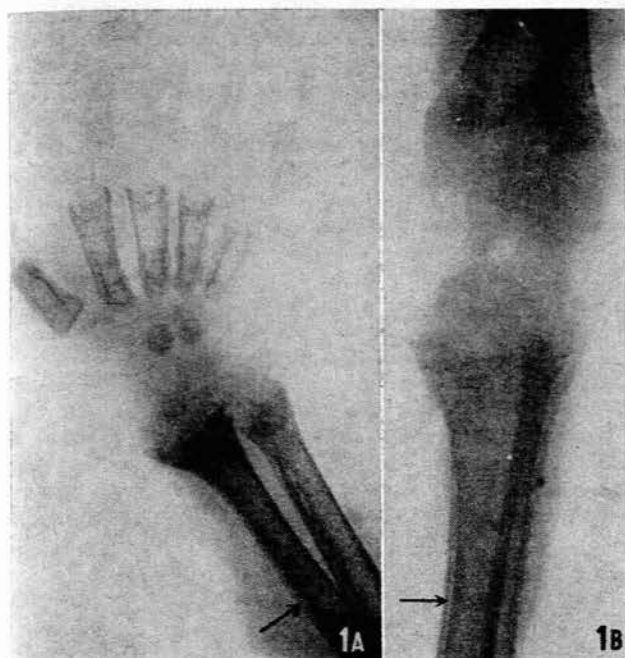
X-rays of patient D.N., aged 1 year 8 months, showing gross rickets with double outline of the cortex (see arrows).
